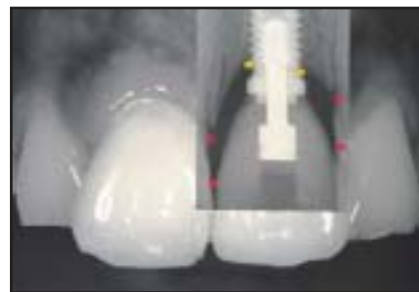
(right) Superimposed radiographic and clinical images of the same restoration demonstrate that the papilla is mainly determined by bone attachment on tooth side.
